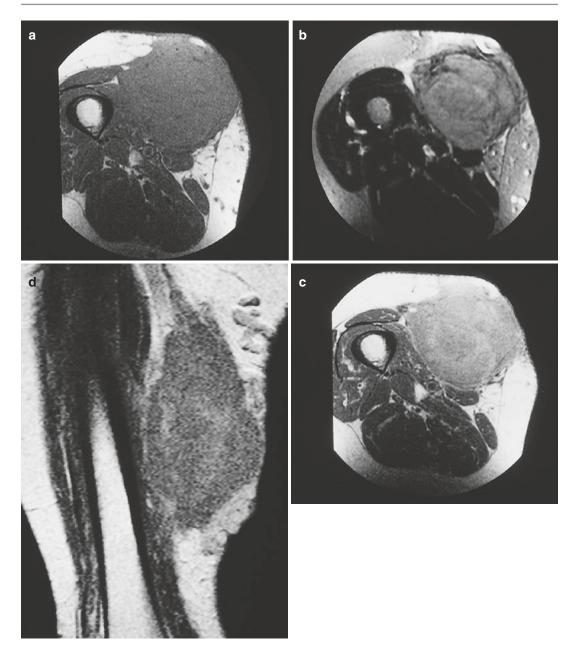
(a–d) Biopsy-proven non-Hodgkin's lymphoma of the quadriceps muscle in a 64-year-old woman: (a) axial spin-echo Tl-weighted MR image; (b) axial spinecho T2-weighted MR image; (c) coronal; (d) axial spinecho T1-weighted MR images after gadolinium contrast injection. On a T1-weighted image, the lesion presents as a nodular mass, infiltrating the fascia and superficial fibers of the rectus femoris, vastus intermedius, and adductor longus muscles. The lesion has a slightly higher signal intensity than adjacent muscle. There is an extensive tumoral spread into the subcutis and cutis resulting in venous obstruction and superficial varices (a). After contrast injection there is a diffuse, moderately heterogeneous contrast enhancement providing a good differentiation between muscle fibers and tumor on TI-weighted images (c, d). On a T2-weighted image, the extent of the lesion can be depicted better owing to the hyperintense appearance relative to the low signal intensity of muscle (b). The T2-weighted or fat-suppressed images also allow better appreciation of venous involvement
